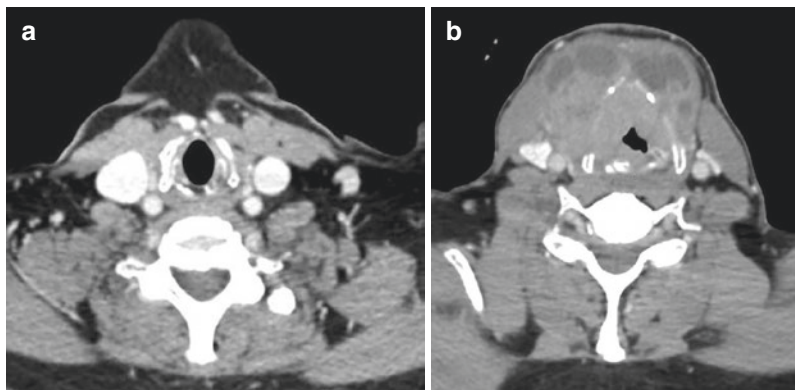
(a) Axial section CT image at level of thyroid cartilage showing normal airway, (b) axial section at same level showing growth and reduced glottic aperture, minimal diameter at axial view used to calculate endotracheal tube size (minimum diameter on axial cut corresponds to
